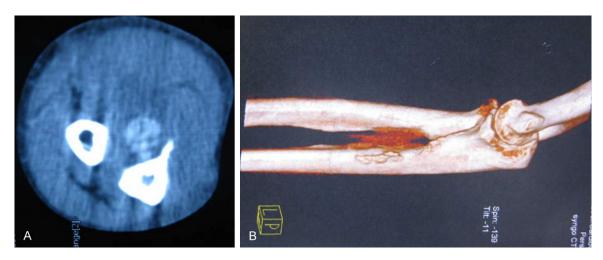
The CT scan showed there was a high-density mass in the middle and upper right ulna (A). The 3D reconstruction of CT scan imagine showed there was a high-density mass in the middle and upper right ulna, considering a pathogenesis of hematoma (B).
